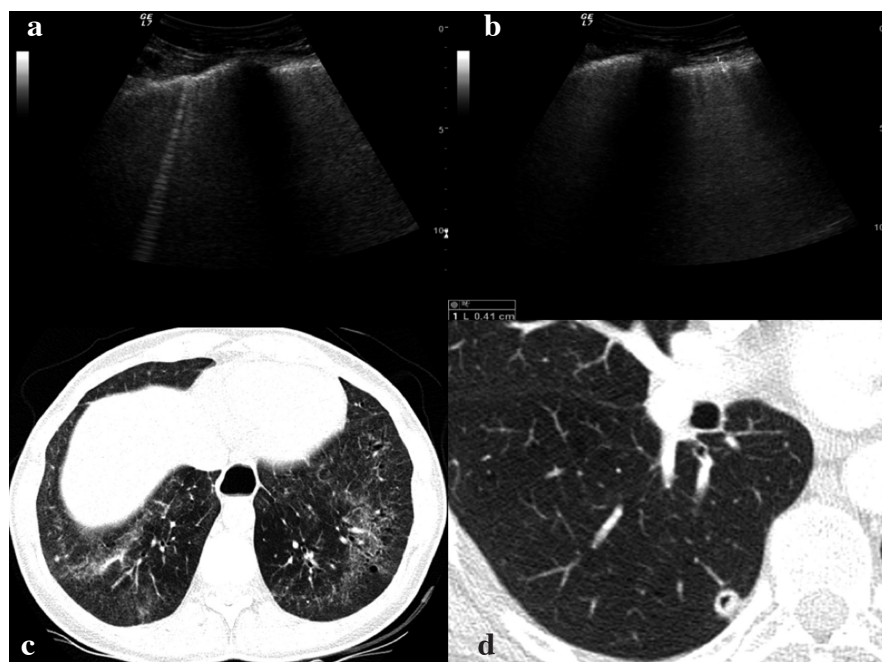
a) B line; b) irregular (unsteady) pleural line of 4.1 mm and subpleural node; c) HRCT scan showing typical changes for ILD including alveolitis, ground glass phenomena and bronchiectasis and d) subpleural node as seen in ILD of rheumatoid arthritis.
